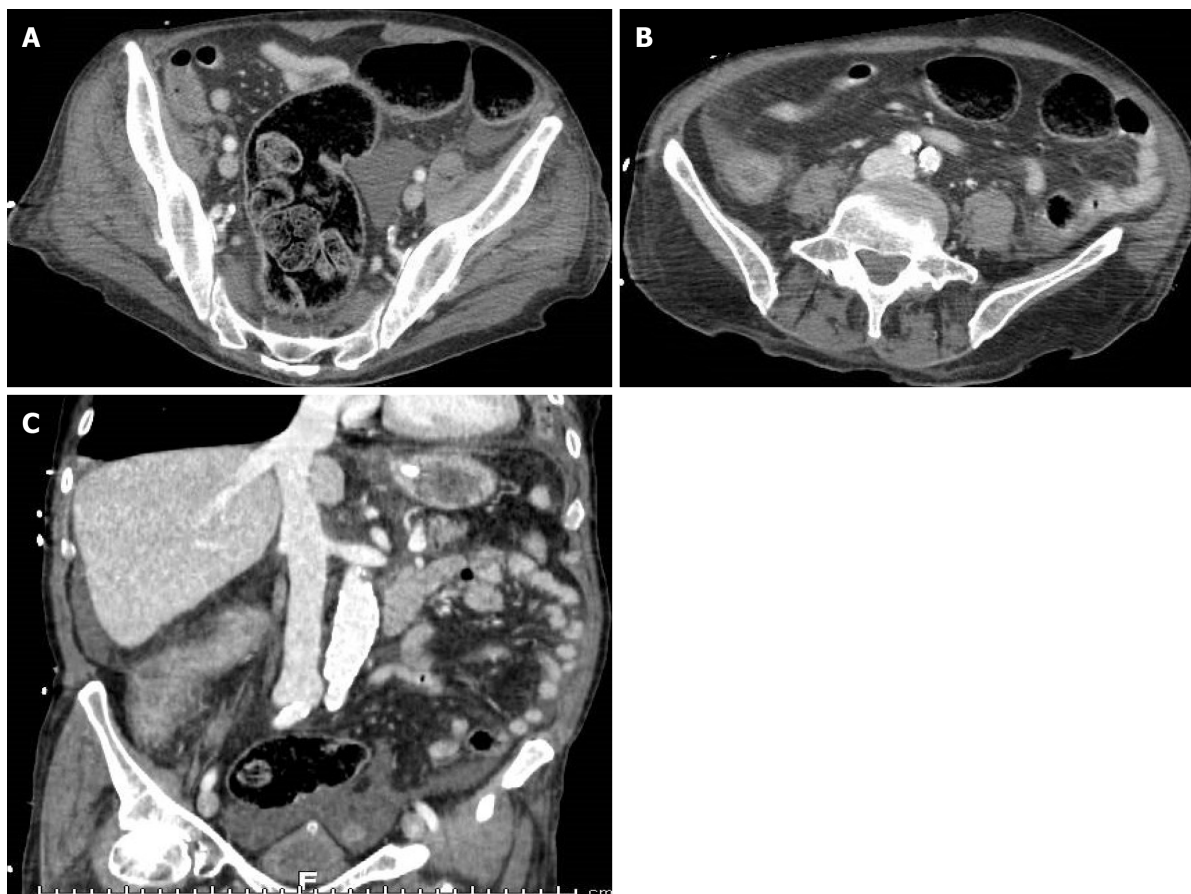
A 73-year-old woman with abdominal pain. A: Contrast-enhanced portal-venous phase computed tomography image of the lower abdomen demonstrated gas distension of the sigma-rectum with evidence of multiple stools inside the lumen; free effusion was also appreciable around the colon; B: Contrast-enhanced portal-venous phase computed tomography image of the abdomen showed distention of the left bowel and hyperemic thickened walls (particularly affecting the mucosa) of the right colon with perivisceral fat suffusion; C: Coronal multiplanar reconstruction from contrast-enhanced computed tomography well demonstrated these findings.
